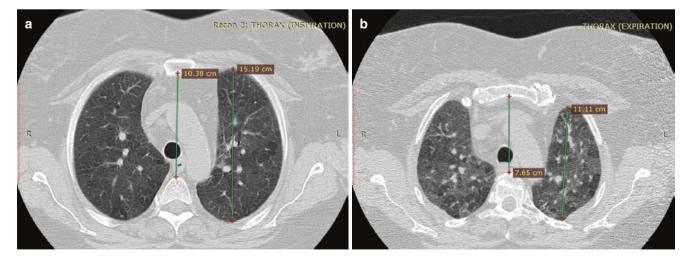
Visual assessment of air-trapping on (a) inspiratory and (b) expiratory CT. Note that the tracheal shape has changed from "O" shape to "D" shape
